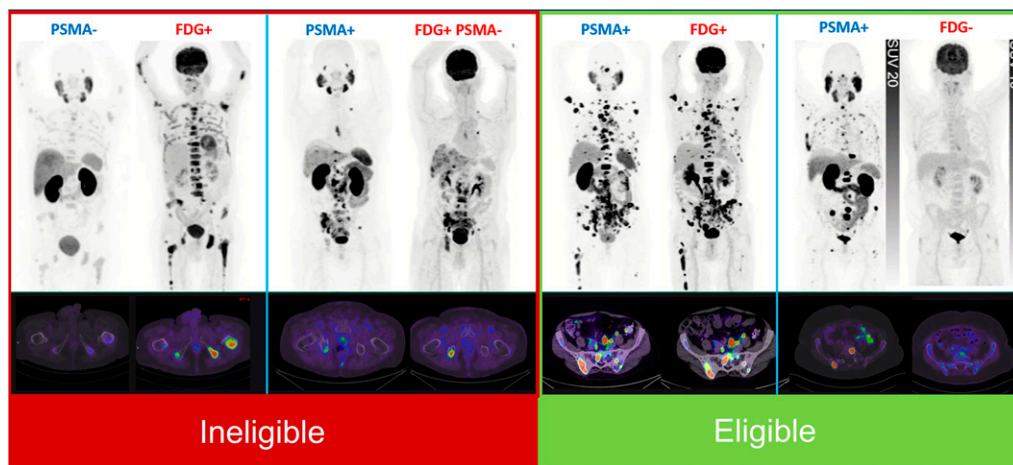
Patient Selection for PSMA-Based Radionuclide Therapy Using Dual-Tracer ^{18}F -Fluorodeoxyglucose and ^{68}Ga -PSMA-11 PET/CT Screening Procedure
